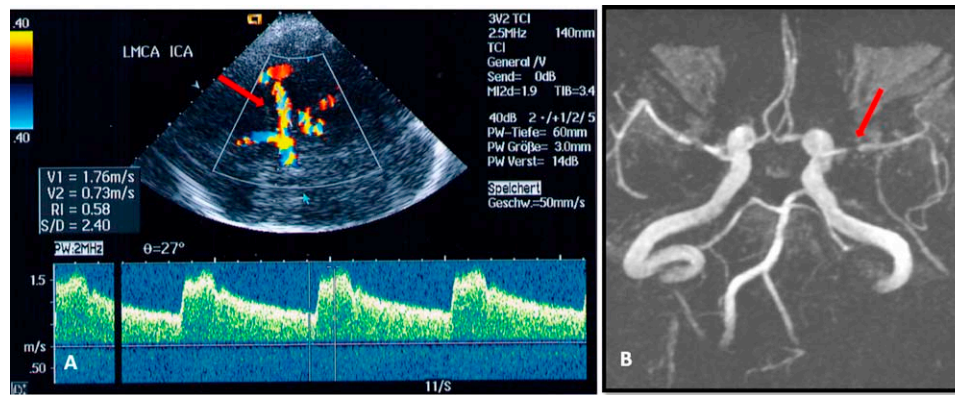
Bilateral MCA stenosis in the case of a 62-year-old-man with vasculitis. (A) Imaging of a moderate stenosis of the left MCA. The sample volume is placed in 60 mm depth (arrow), V1 = maximum systolic velocity (178 cm/s). An aliasing phenomenon can be seen in all visualized arteries because of the setting of the color scale by 40 cm/s mean blood flow velocity. (B) MRA of the bilateral MCA stenosis (the arrow indicates the sonographically examined artery). (MRA image: Courtesy - Radiologie Dr. Sollfrank, München, with permission.)
